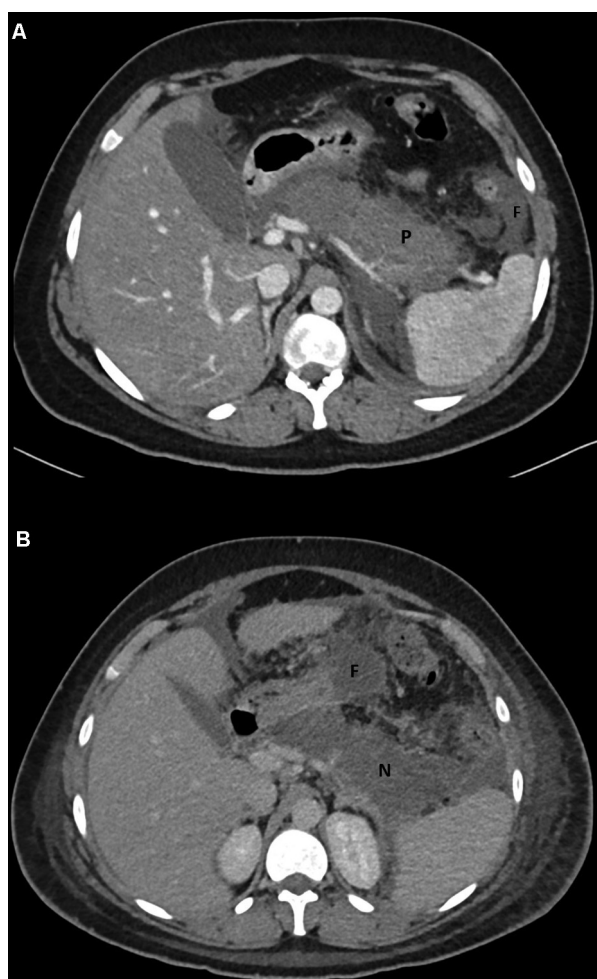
Computed tomography (CT) in a 20/M with acute alcohol-related necrotizing pancreatitis due to high-intensity drinking. (A) Contrast-enhanced CT (CECT) in axial plane shows bulky pancreas (P) and hypoenhancement of the parenchyma. No definite necrotic areas could be identified. F represents peripancreatic acute fluid collection. (B) CECT done at 1 week follow-up, shows necrosis of the entire body and tail with nonenhancement (N). F represents peripancreatic acute fluid collections.
